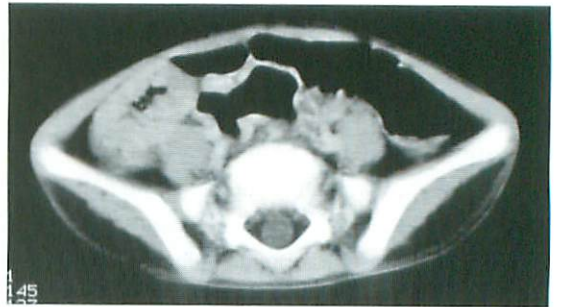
Contrast-enhanced computed tomography of the abdomen on 2nd hospital day revealed thickening of the ascending colon.
